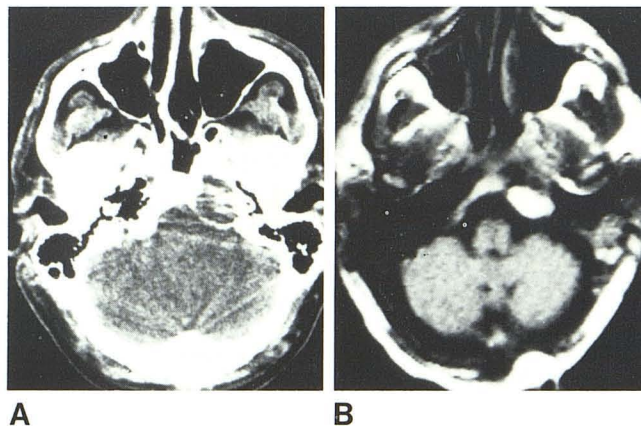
Teratoma of petrous apex. A, CT shows destructive lesion in left petrous apex. B, SE image using variable parameters revealed high-intensity lesion at this site, with T_1 and T_2 values consistent with fat. Biopsy showed teratoma with lipomatous component.
